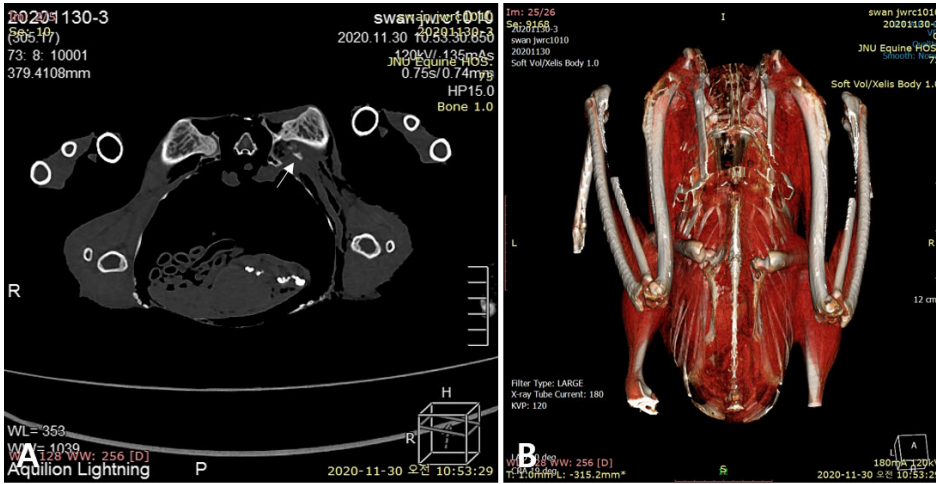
Computed tomography of whooper swan in sternal recumbency, bone window; left femoral luxation and avulsion fracture of femoral head with emphysema and soft tissue swelling surrounding the hip joint. A few pieces of small fragments (arrow) (A). Dorsal view of the three-dimensional model of whooper swan. On a 3D image, the left coxofemoral joint was accurately confirmed to be a craniodorsal dislocation (B).
